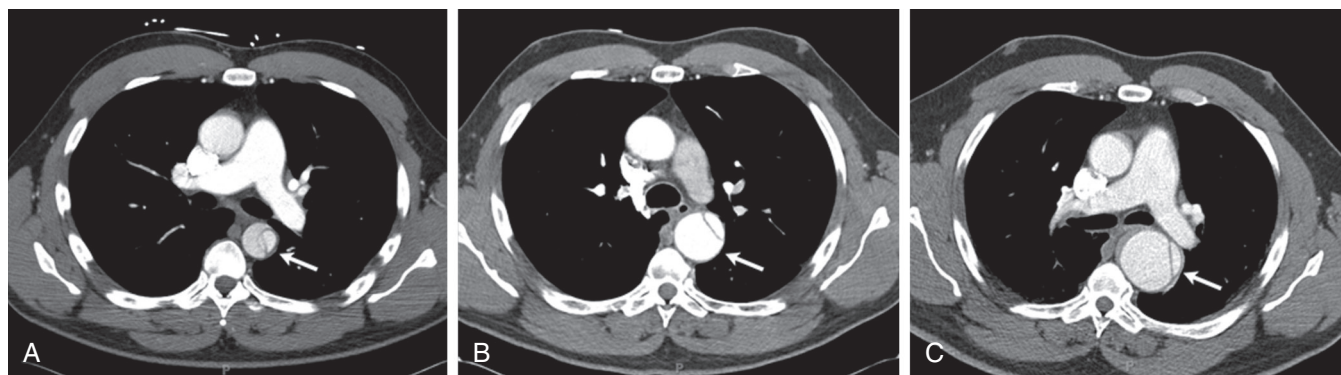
FIGURE e57-18 Progressive aneurysmal enlargement of the descending aorta following type B aortic dissection. A, CT scan demonstrating acute type B aortic dissection (*arrow*). B, The false lumen (*arrow*) has dilated 1 year after the acute dissection. C, Further enlargement of the false lumen (*arrow*) with aneurysmal enlargement 3 years after the acute dissection.
